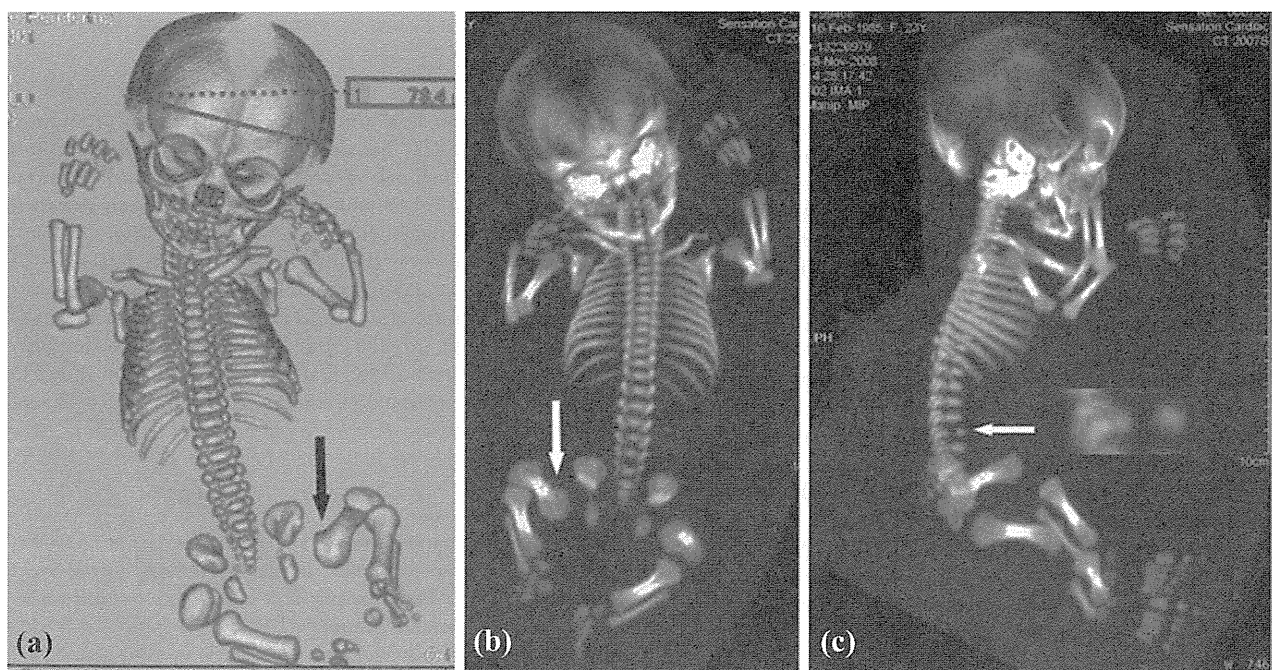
Images of helical CT of the fetus. (a) Frontal image of 3D-VR showing platyspondyly, shortness of the limbs and dumbbell appearance (an arrow) of tubular bones. (b) Frontal image of MIP showing prominent broad metaphyses (an arrow) resulting from splaying, which strongly suggested a diagnosis of Kniest dysplasia. (c) Lateral image of MIP showing coronal cleft in the 4th lumbar vertebral body (an arrow) and prominent broad metaphyses. Magnification of the coronal cleft is shown to the right of the arrow.
